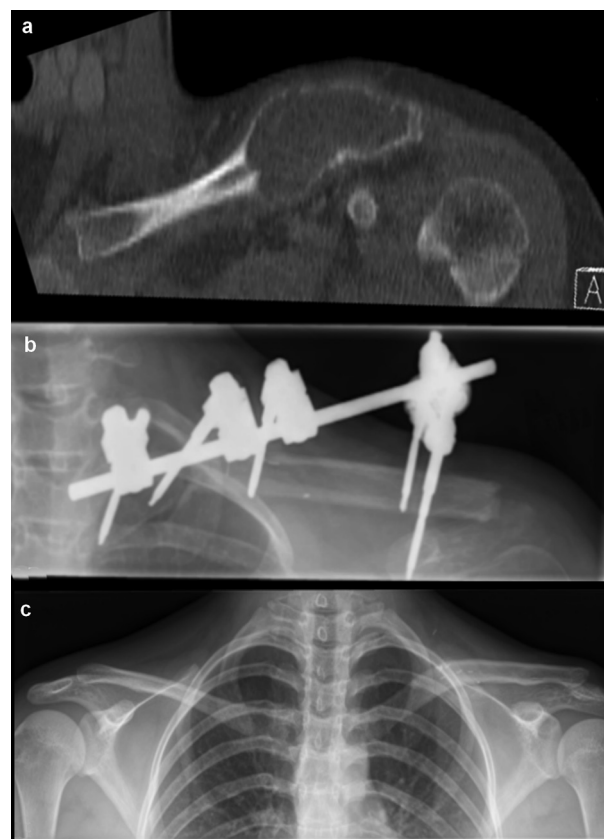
X-ray series: pre-operative CT (a), post-operative fixation (b), and long term follow-up panoramic shoulder view (c).
